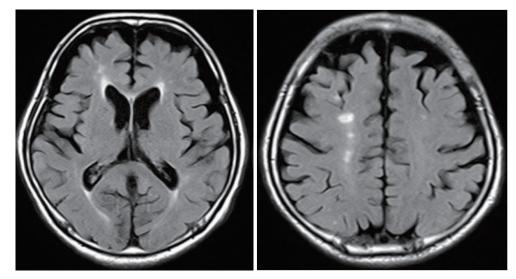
Postoperative cerebral fluid-attenuated inversion recovery magnetic resonance imaging on postoperative day 90 showing no new structural lesions.
